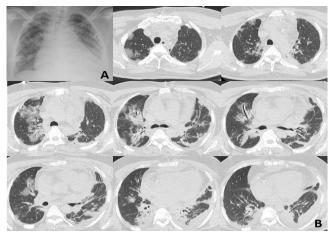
Bedside chest X-rays of suspected COVID-19 (A) and a chest computed tomographic scan revealed the presence of bilateral peripheral ground-glass opacities (B)
